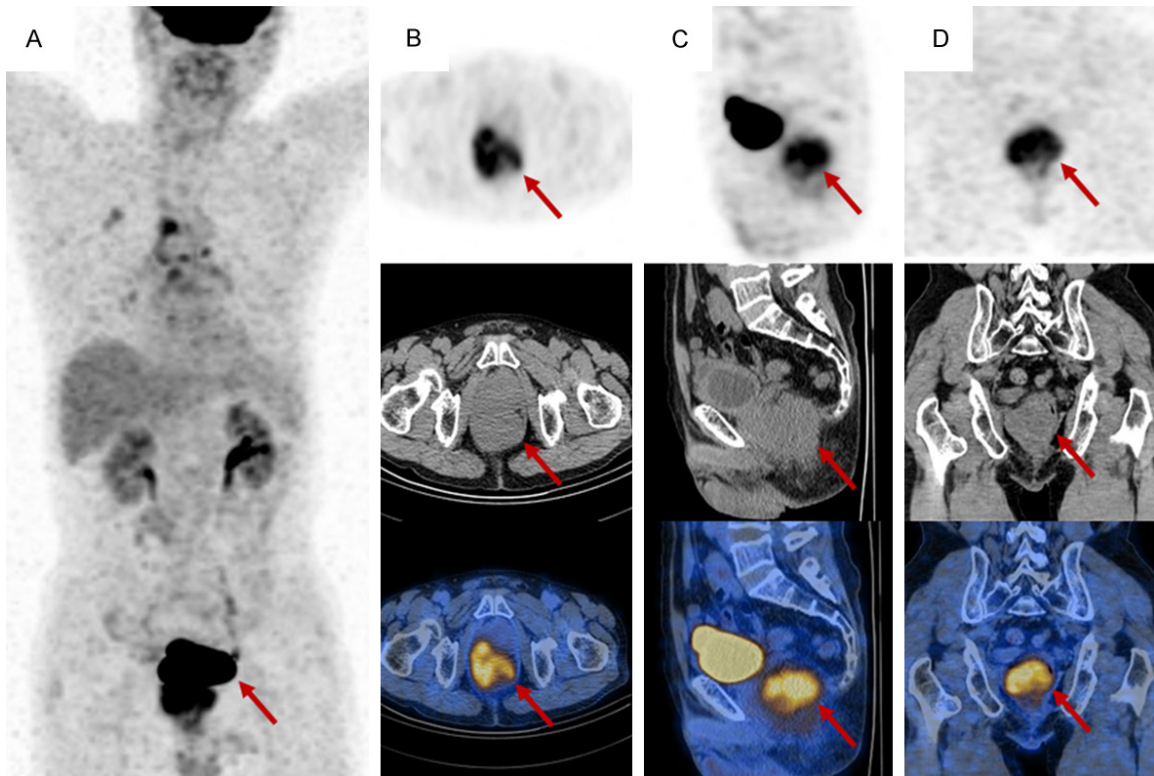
^{18}F -FDG PET/CT images. (A) The whole-body maximum intensity projection showed the hypermetabolic lesion of the rectum. (B) Pelvic transverse, (C) Sagittal and (D) Coronal images showed a soft tissue density mass at the bottom of the pelvic, with an unclear boundary to the rectum and right seminal vesicle. Increased FDG uptake of the lesion was observed with SUVmax 17.5.
